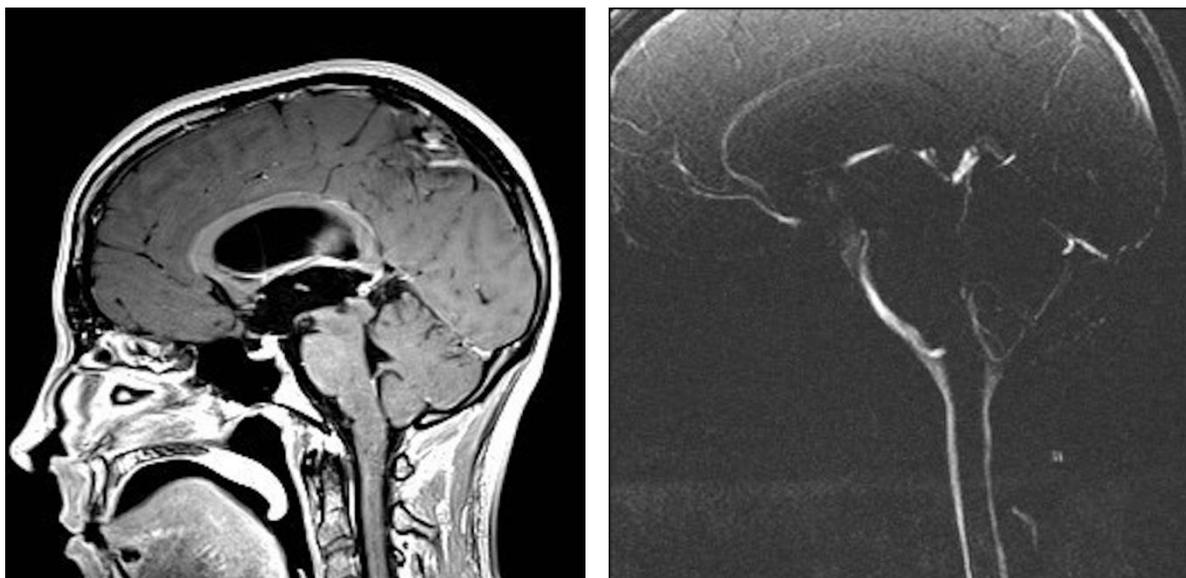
Spontaneous third ventriculostomy (STV) on MR imaging. A: Sagittal sequence (inverse) showing defect in the floor of the third ventricle, B: CSF flow sequences demonstrating flow across the floor of third ventricle in same patient.
